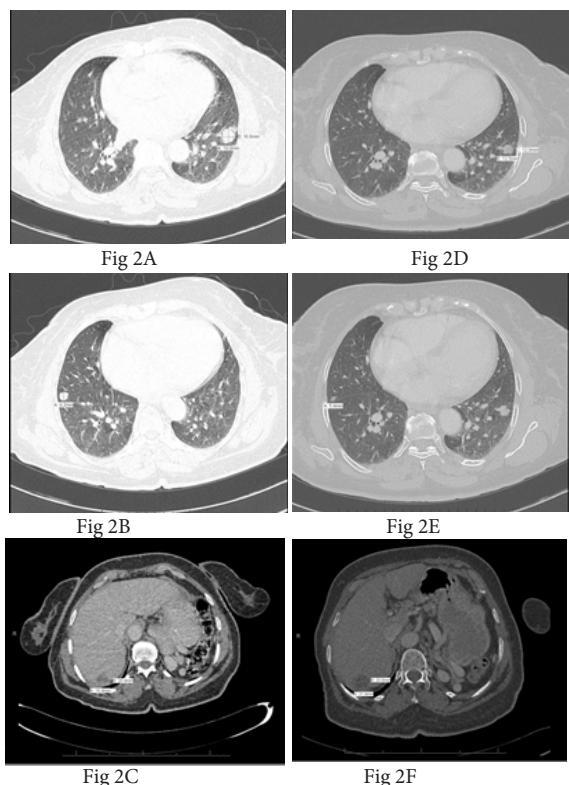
Staging CT scan at the time of the diagnosis of breast cancer. Figures 1A, B and C metastatic lesions in left middle zone of lung, right middle zone of lung and the liver respectively, which regressed after 10 months of treatment with letrozole, as shown in figures 1D, E and F in the corresponding areas.
